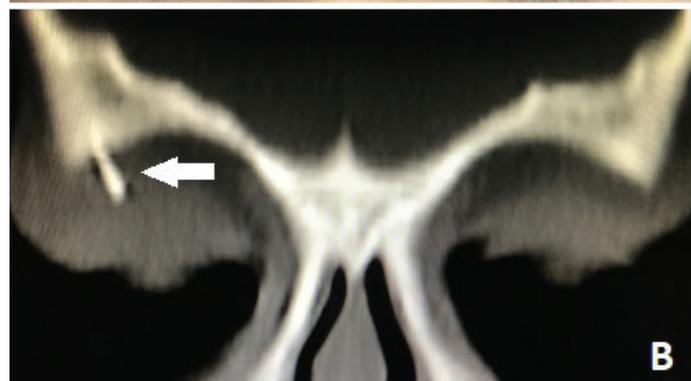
Case 3. A) A mass on his right upper eyelid B) Computed tomography image of case 3
